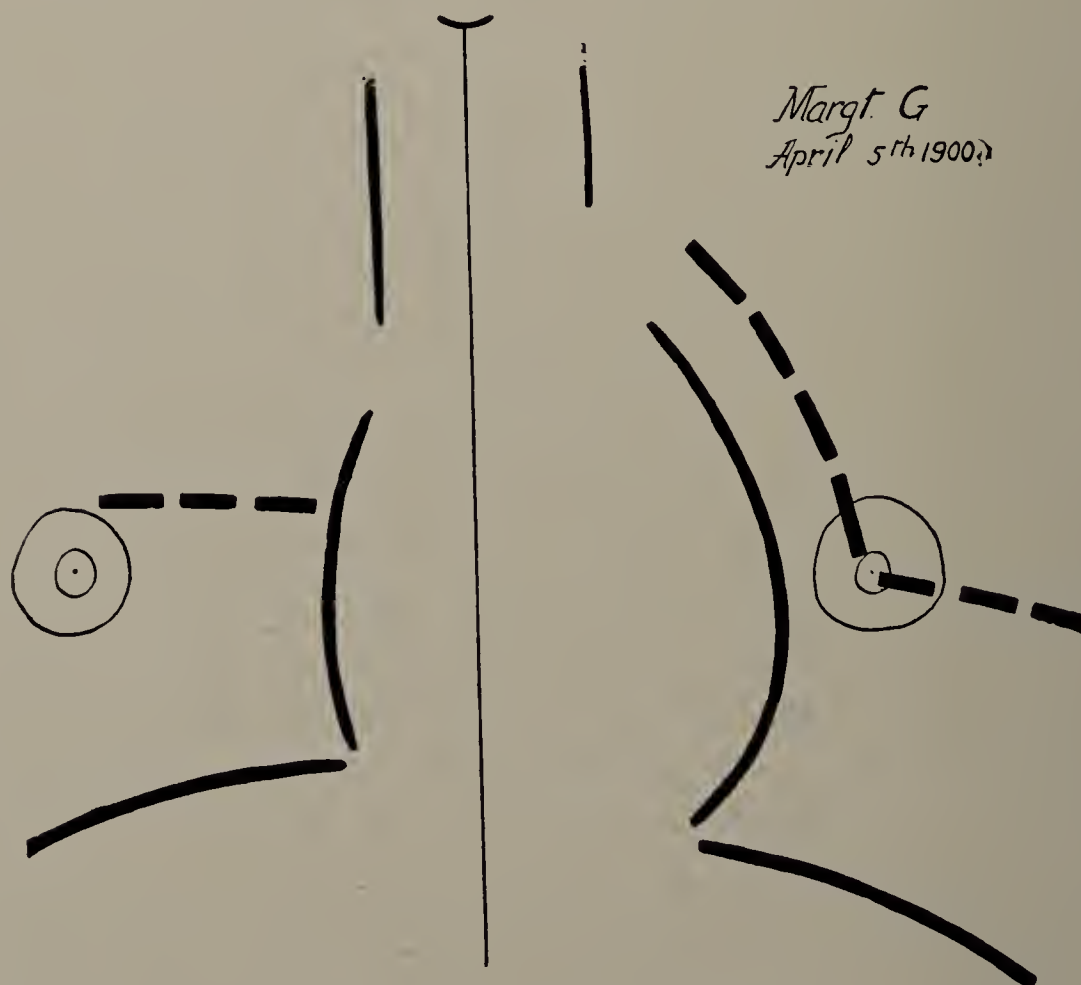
Margaret G. X-ray tracing made April 5, 1900. (One-third life size.) Chest nearly normal.
